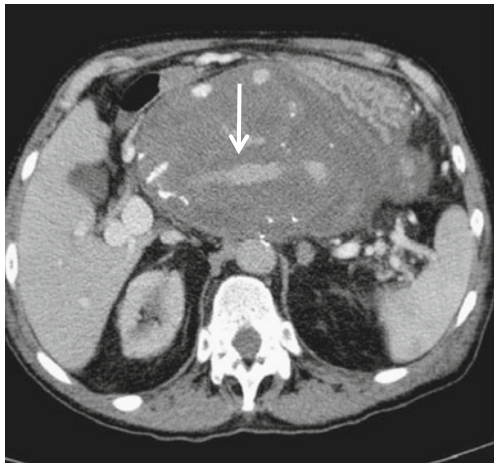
CT angiogram: axial view of the 18-cm partially calcified giant splenic artery pseudoaneurysm lying posterior to the stomach and anterior to the aorta. Contrast enhancement of blood flow within the pseudoaneurysm is noted. The *arrow* points to the false channel
